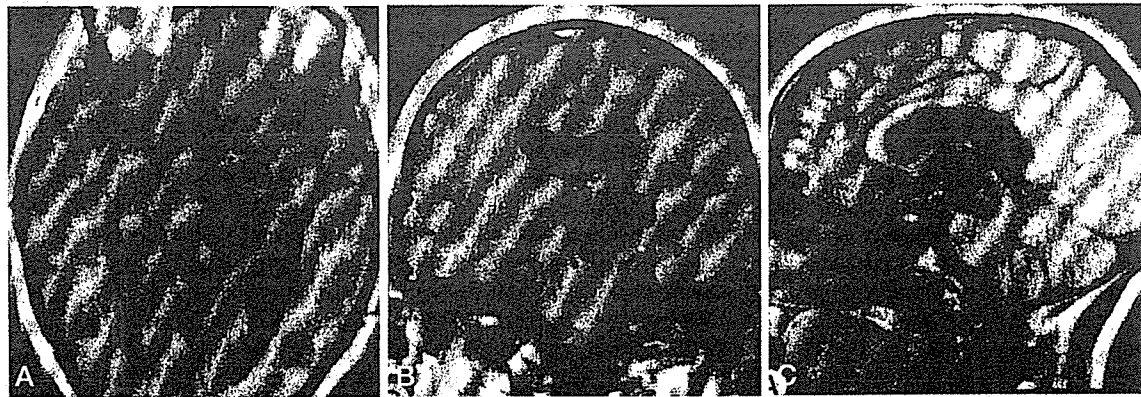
reference from 39 (reproduced with permission). T1 weighted axial (A), coronal (B) and sagittal (C) images, revealing multilobular CSF-filled expanding spaces at the mesencephalo-diencephalic junction. A 32-year-old female presented with headache and progressive right hemiparesis and MR images revealed multilobular CSF-filled expanding spaces at the mesencephalo-diencephalic junction with ventricular dilatation. She underwent endoscopic fenestration of cyst wall and became free of the neurological deficits.
